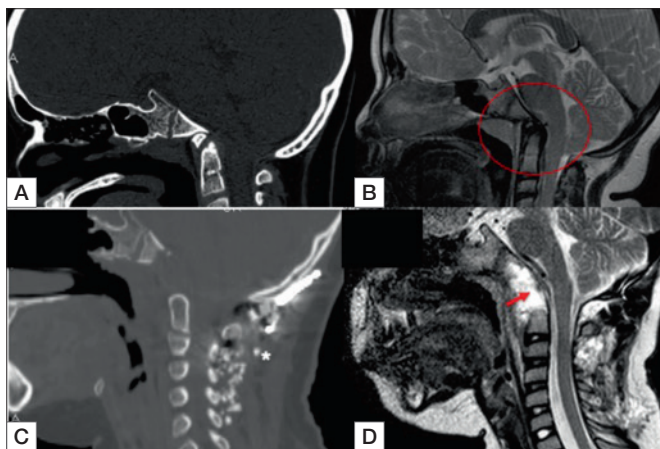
Axial CT scan (A) and T2 weighted MRI (B) of platybasia and impressio basilaris with bulbo-medullar compression (rounded area) treated through a pure transnasal endoscopic approach. In the inferior line post-operative CT scan (C) and MRI (D) showing a decompression of the bulbopontine (arrow) angle and the posterior stabilization (*) the absence of tracheostomy can be also observed.
